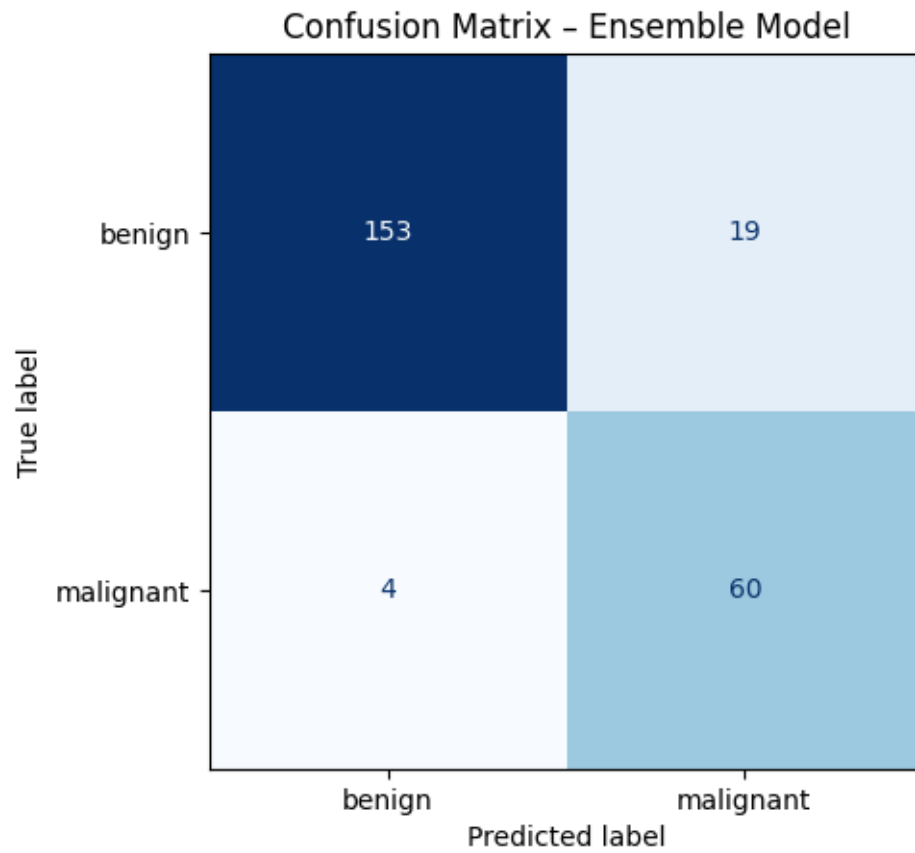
Confusion Matrix of the Ensemble Model Showing Classification Results for Benign and Malignant Breast Ultrasound Images.
